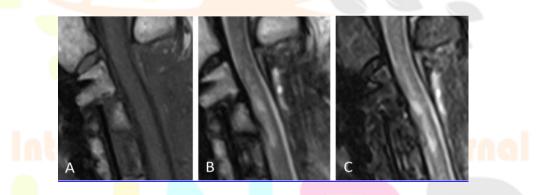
Myelomalacia. (A) Sagittal T1-weighted image in a patient with cervical decompression and anterior/posterior spinal fusion. Based on a prior CT scan (not shown), the fusion is solid. (B) Sagittal T2 and (C) sagittal STIR images demonstrate noncystic T2 hyperintensity in the spinal cord between C3 and C5 with cord thinning, compatible with myelomalacia. There is no corresponding signal abnormality in the cord on the T1-weighted image, unlike in the previously seen case of posttraumatic cyst.
